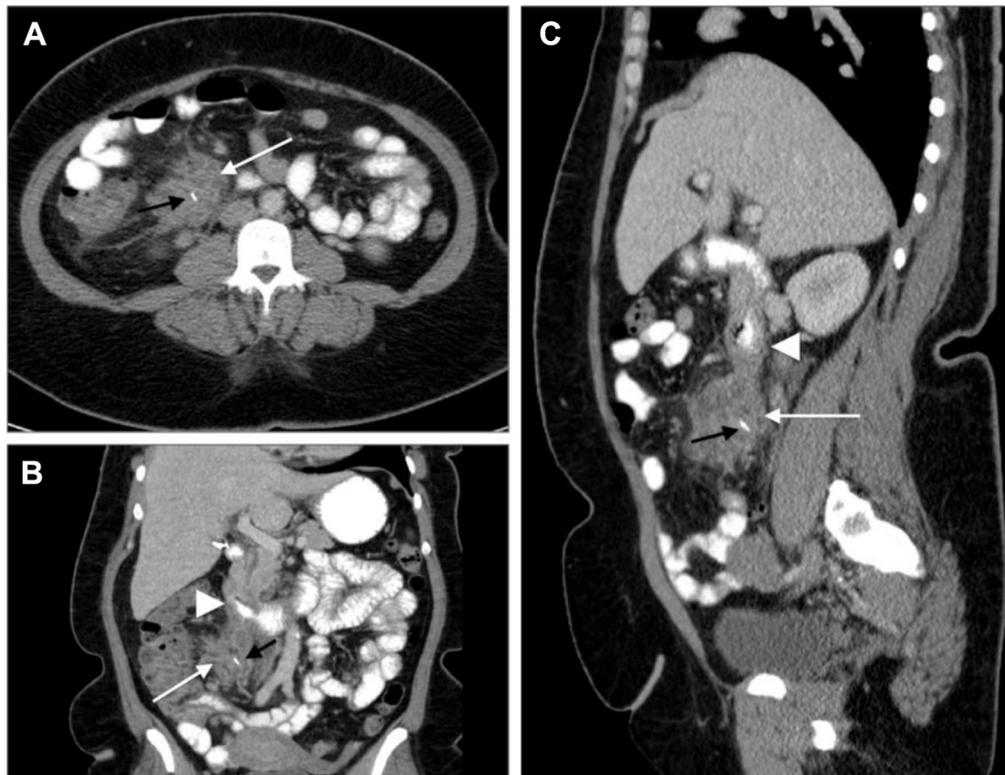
Patient who swallowed a chicken bone and presented several days later with severe pain. Axial (A), coronal (B), and sagittal (C) contrast-enhanced CT showing a heterogeneous phlegmon (white solid arrows in A, B, and C) inferior to, but contiguous with, the second-third portion of the duodenum (arrowheads in B and C). In the center of this collection, there is a thin hyperdense chicken bone (black solid arrows in A, B, and C).
